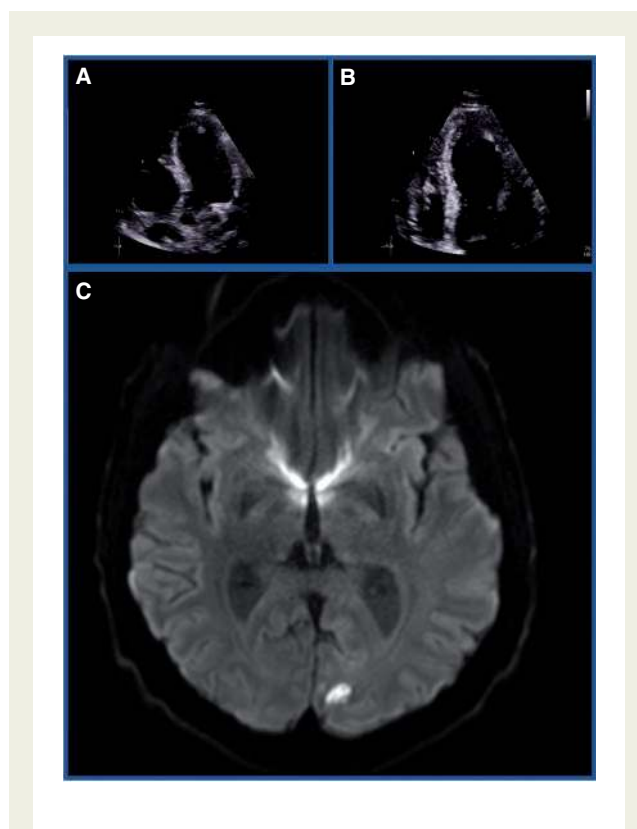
Transthoracic echocardiography with evidence of apical thrombus (A, B). Brain magnetic resonance image showing a small left occipital infarct area with no signs of haemorrhagic transformation (C).
